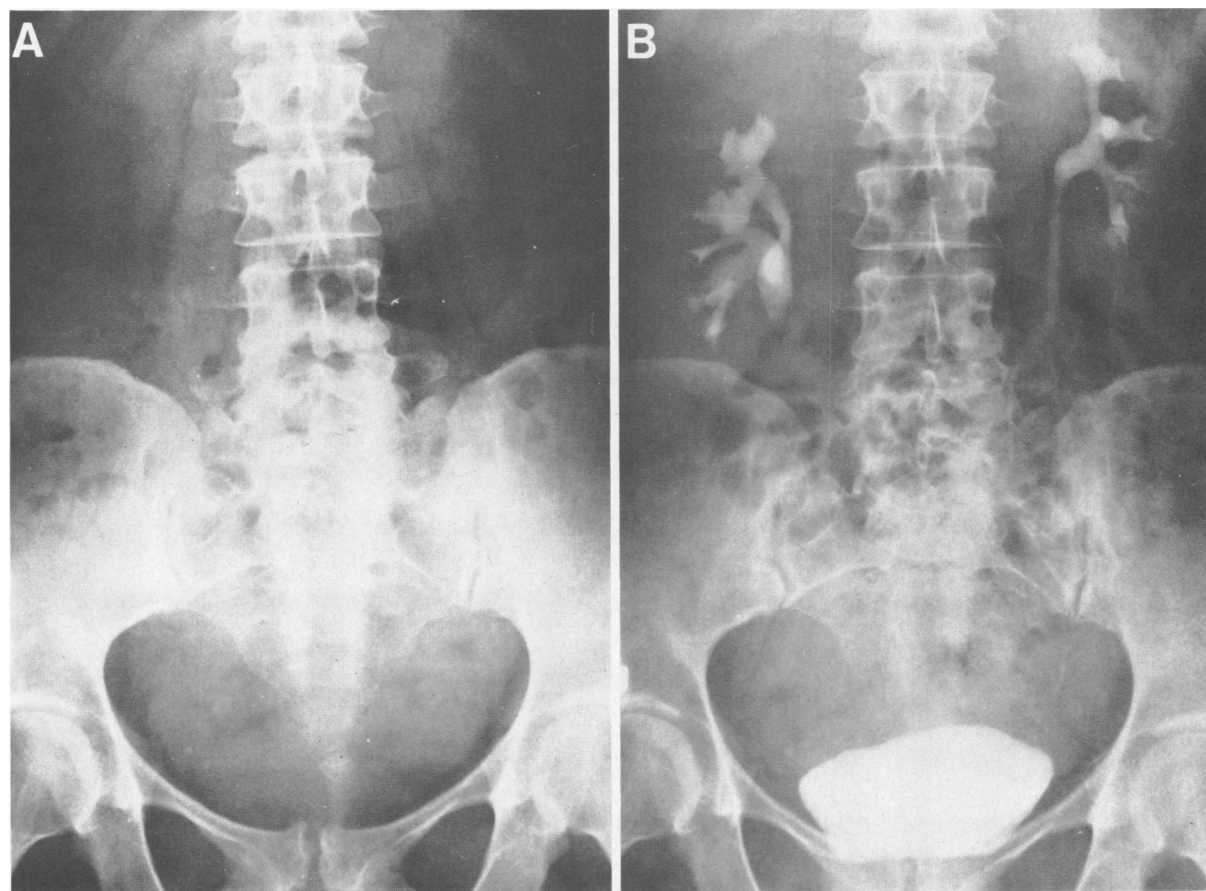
(Case 1) A, Postoperative plain film showing complete removal of staghorn calculus. B, Excretory urogram three months after nephrolithotomy showing mild residual dilatation of right collecting system.
